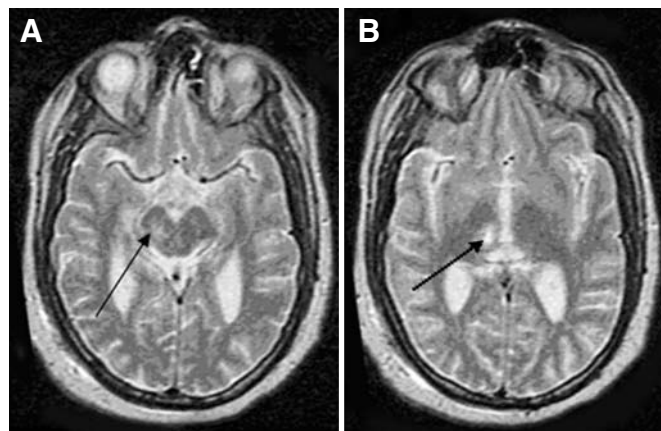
T2-weighted MRI scans obtained from Patient 3 24 hours after MRIGFUS treatment showing the new hyperintense signal in the upper midbrain (A) and diencephalic regions (B) (arrows).
